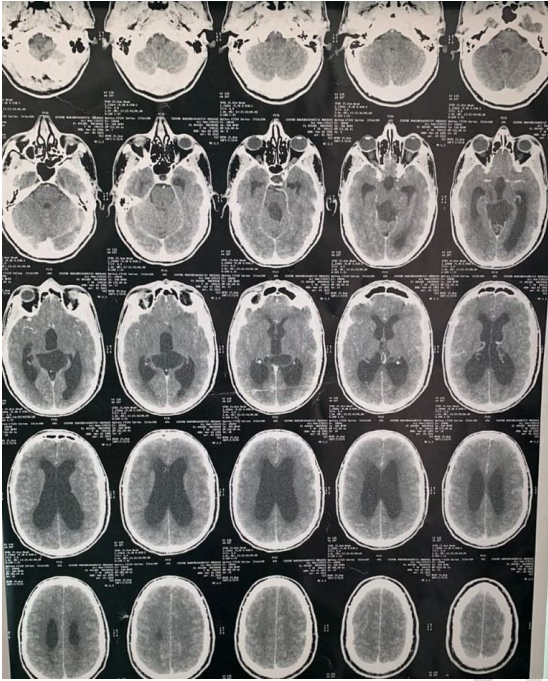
Brain CT C+ axial sections showing a lesion in the hypodense pineal region that does not take up the contrast.
